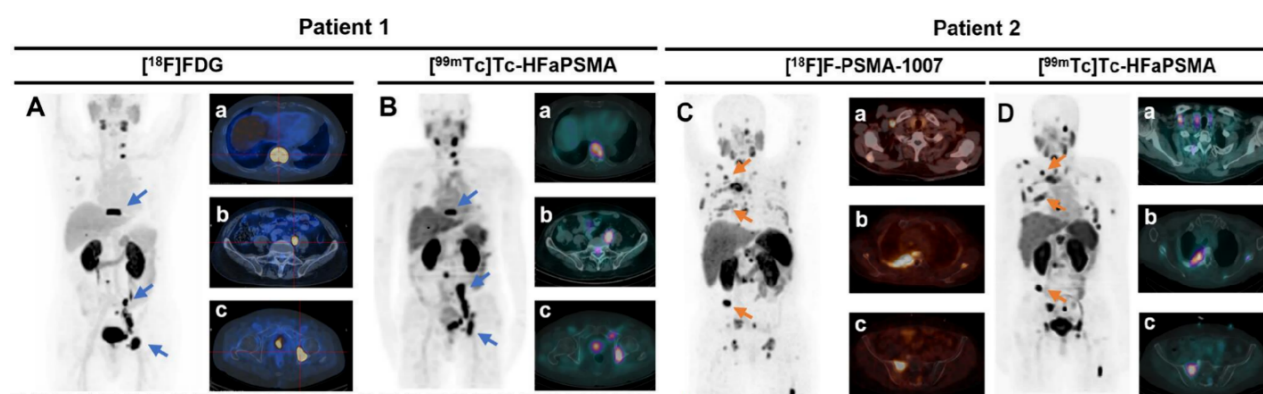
Positron emission tomography/computed tomography (PET/CT) and single-photon emission computed tomography (SPECT)/CT images of two prostate cancer patients. Maximum-intensity-projection (MIP) images and three representative merged transverse images of $[^{18}\text{F}]\text{FDG}$ (A) and $[^{99\text{m}}\text{Tc}]\text{Tc-HFaPSMA}$ (B) in a 78-year-old patient. Fused axial image showing thoracic nine cone metastases (a), retroperitoneal lymph nodes (b), and left acetabulum (c). MIP images of $[^{18}\text{F}]\text{F-PSMA-1007}$ (C) and $[^{99\text{m}}\text{Tc}]\text{Tc-HFaPSMA}$ (D) in a 63-year-old patient. Fused axial image showing the right supraclavicular fossa lymph node (a), the right 3 posterior ribs (b), and the right sacroiliac joint (c). Arrows from top to bottom correspond to the right fusion axial image. Reprinted with permission from Wang *et al.*⁶⁰ Copyright © 2025 American Chemical Society.
